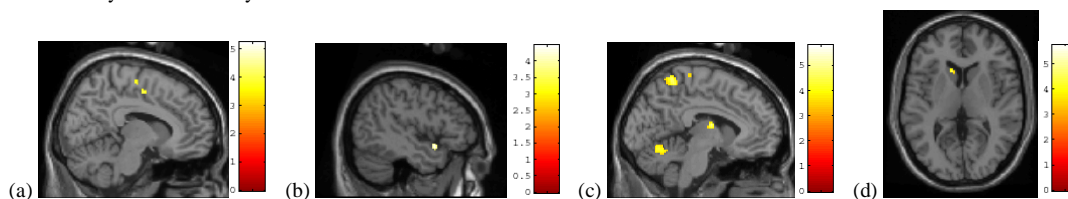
Patients activated more than controls (a) in the right SMA and cingulate cortex during right active movement (MNI $x=10, y=-6, z=50$), (b) in the left superior temporal gyrus during right passive movement ($x=-44, y=8, z=-10$), (c) in the left precuneus, left SI-MI, superior vermis and left thalamus during left active movement ($x=-6, y=-31, z=70$), (d) in the left caudate during left passive movement ($x=-10, y=20, z=6$). Results are overlaid onto T1-weighted template and corrected for multiple comparisons. The colour scale indicates the T score.
